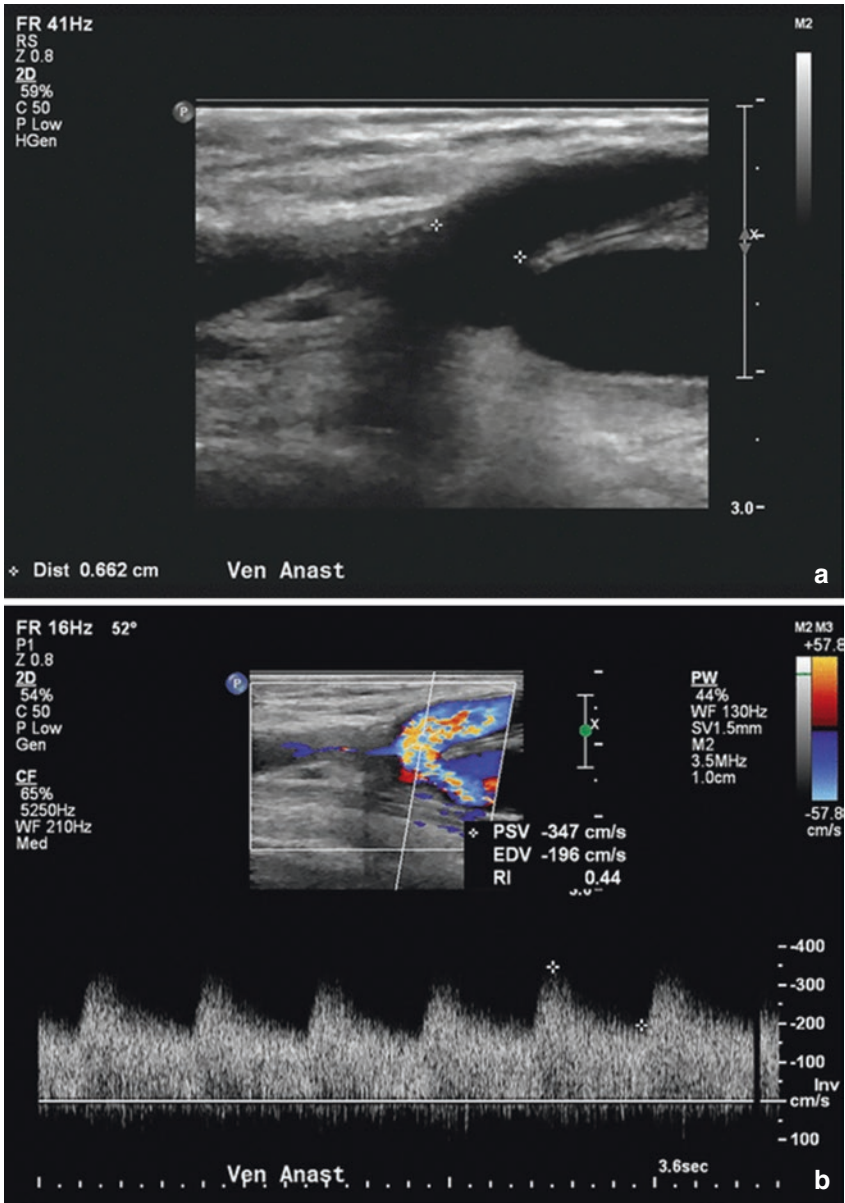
(a) Gray scale image demonstrating the venous anastomosis measuring 6.6 mm, as well as a high grade juxta-anastomotic stenosis with marked reduction of luminal diameter. (b). Duplex Doppler image of the venous anastomosis demonstrating PSV of 347 cm/s and EDV of 196 cm/s. (c) Magnified color Doppler image demonstrating the high grade juxta-anastomotic stenosis with only a trace of color flow through the stenosis along with elevated velocity of 450 cm/s. Note the neointimal hyperplasia seen as a smudgy gray area on either side of the stenotic flow lumen (yellow arrow) and elevated velocity at the site of stenosis of 450 cm/s (d). (e) Duplex Doppler image of the outflow vein immediately central to the stenosis demonstrating a marked reduction in velocity of 50 cm/s
